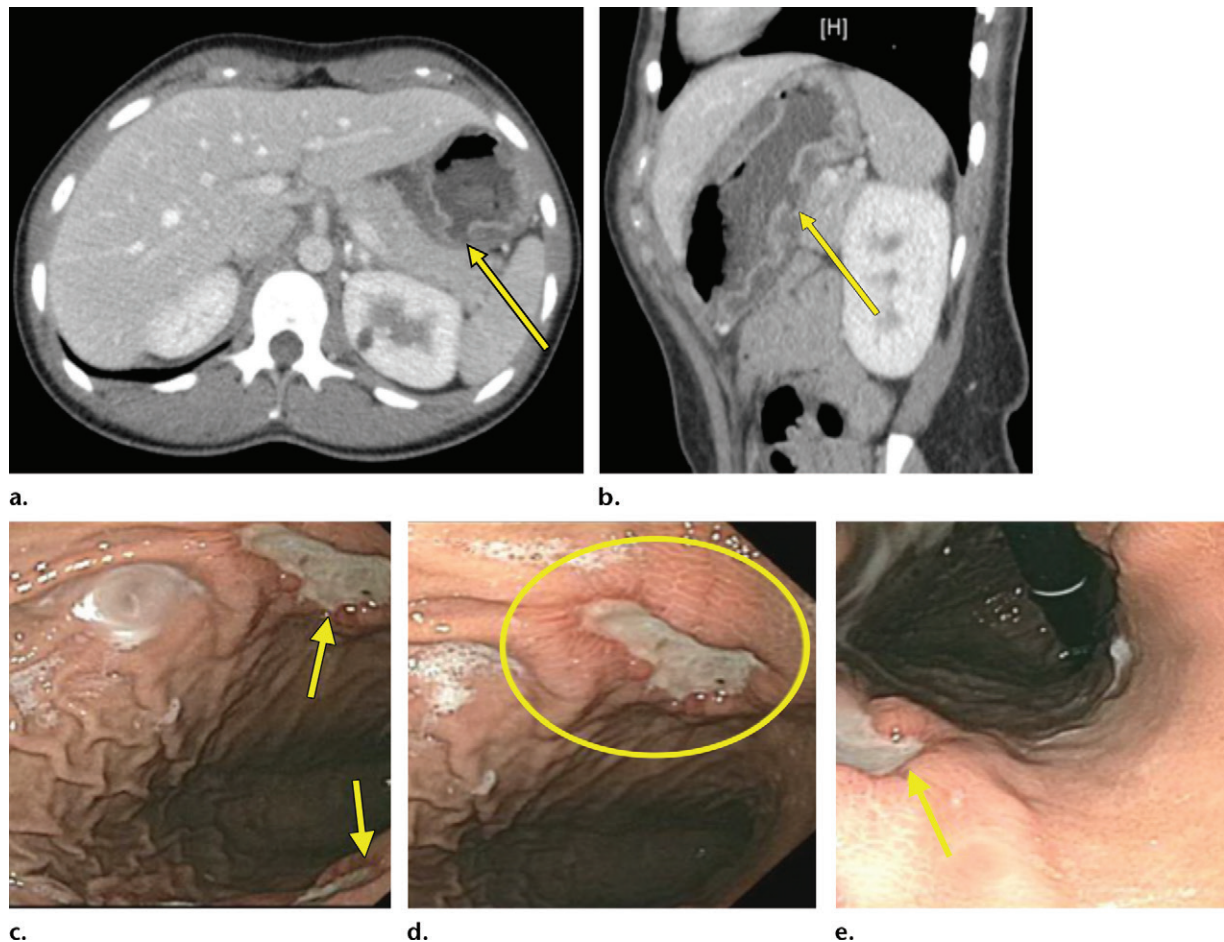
Discontinuous bowel wall in a 25-year-old female go-cart racer who presented with epigastric pain and melena after a crash in which the upper portion of her abdomen impacted the steering wheel. (a, b) Axial (a) and sagittal (b) contrast-enhanced multidetector CT images through the upper part of the abdomen show submucosal edema in the stomach, with a small ulceration posteriorly (arrow). (c–e) Upper endoscopic images show posttraumatic opposing ulcers (arrows on c and e; oval on d) on the anterior and posterior walls of the stomach.
